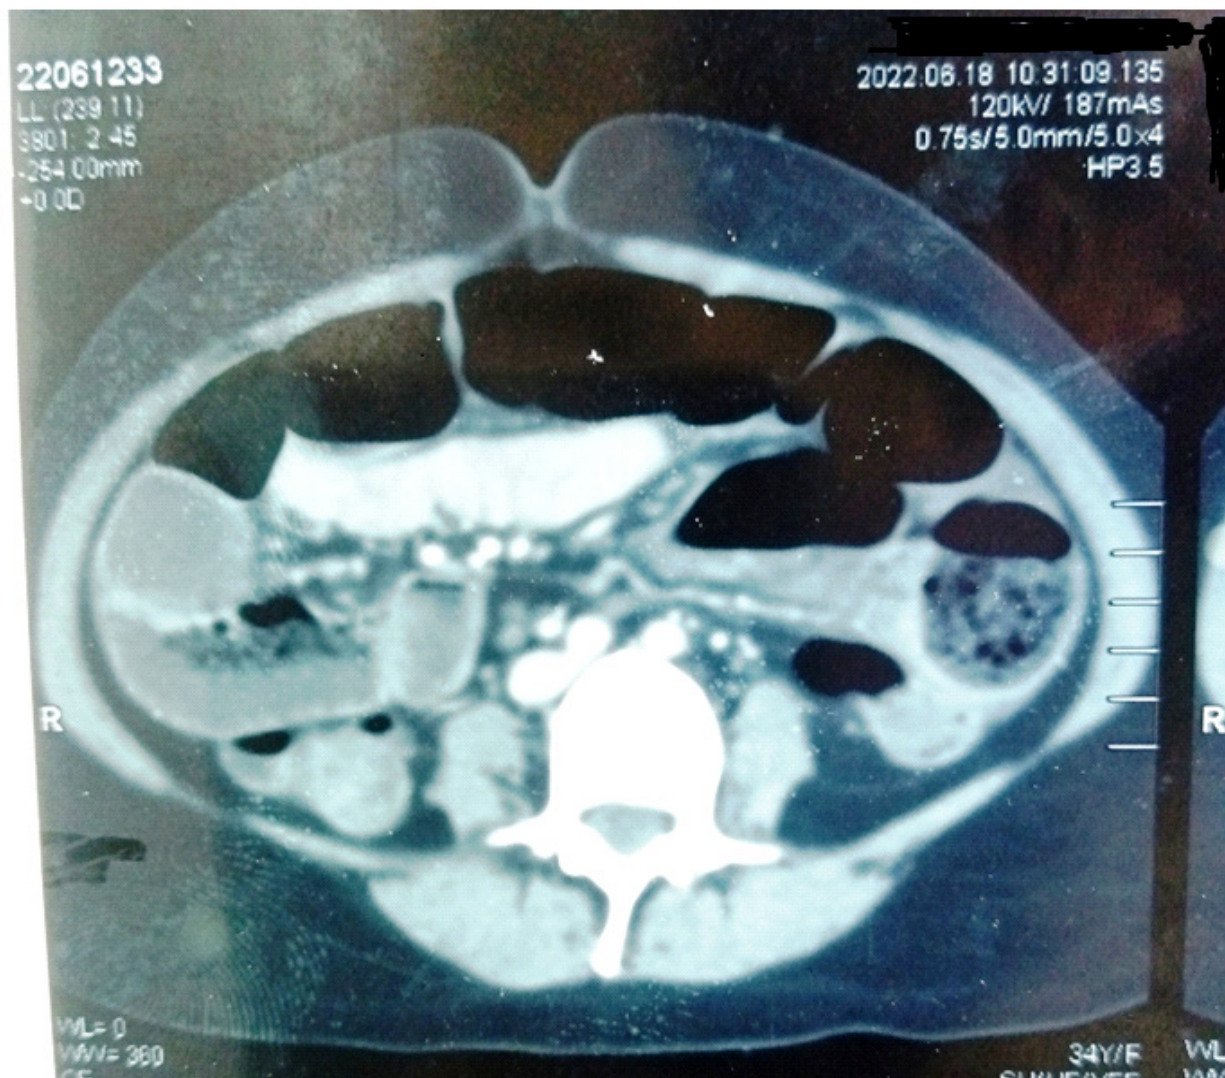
Contrast CT scan of the abdomen showing distended gut loops with air-fluid levels
